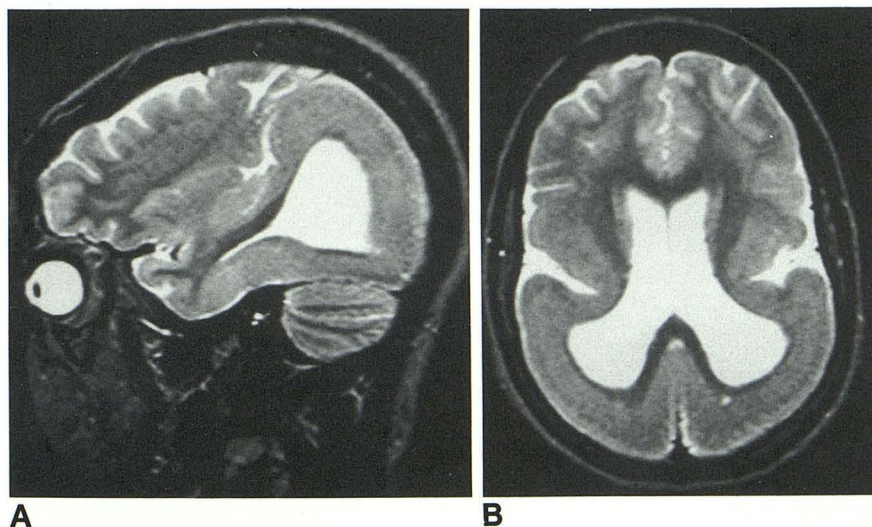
Migration disorder; 14-year-old girl with psychomotor retardation and epilepsy. T2-weighted parasagittal and transverse images show a combination of an occipital lissencephaly and frontotemporal pachygyria, with linear heterotopia of the gray matter in the frontal lobes. Irregularities around the occipital horns suggest an encephaloclastic or toxic cause for the arrest of development.
